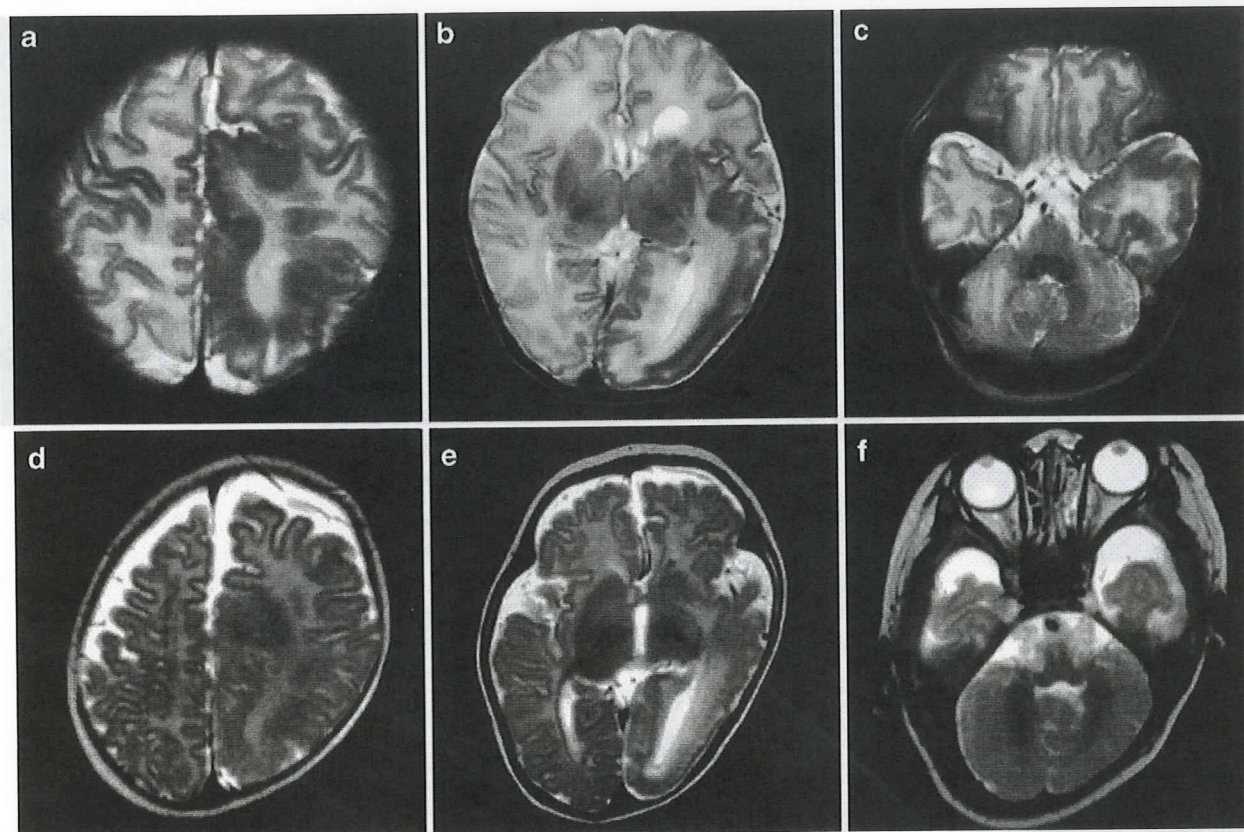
Follow-up MR images of a boy with left localized megalencephaly in whom seizures commenced at 2 days of age and continued at a frequency of approximately ten to 20 per day (grade 2). a, b At 2 weeks of age, an axial T2-weighted image demonstrates that the parietal, posterior, and temporal lobes are enlarged in the left
